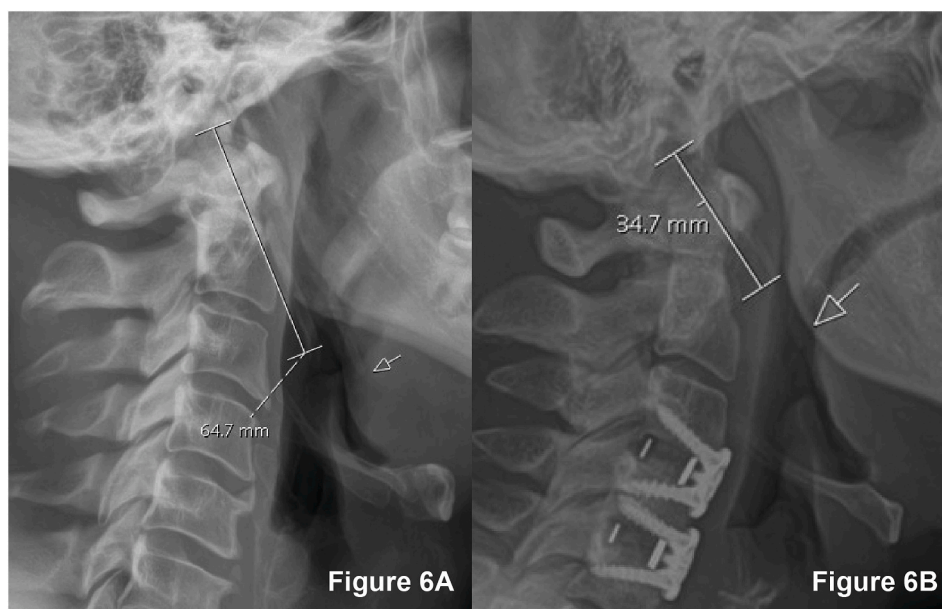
Lateral Cervical Radiographs of two subjects with elongated styloid processes. Fig. 6A has a styloid length of 64.7 mm. The arrow points to the second elongated styloid. Fig. 6B has a styloid length of 34.7 mm. The arrow points to calcifications extending down from the styloid toward the hyoid bone.
